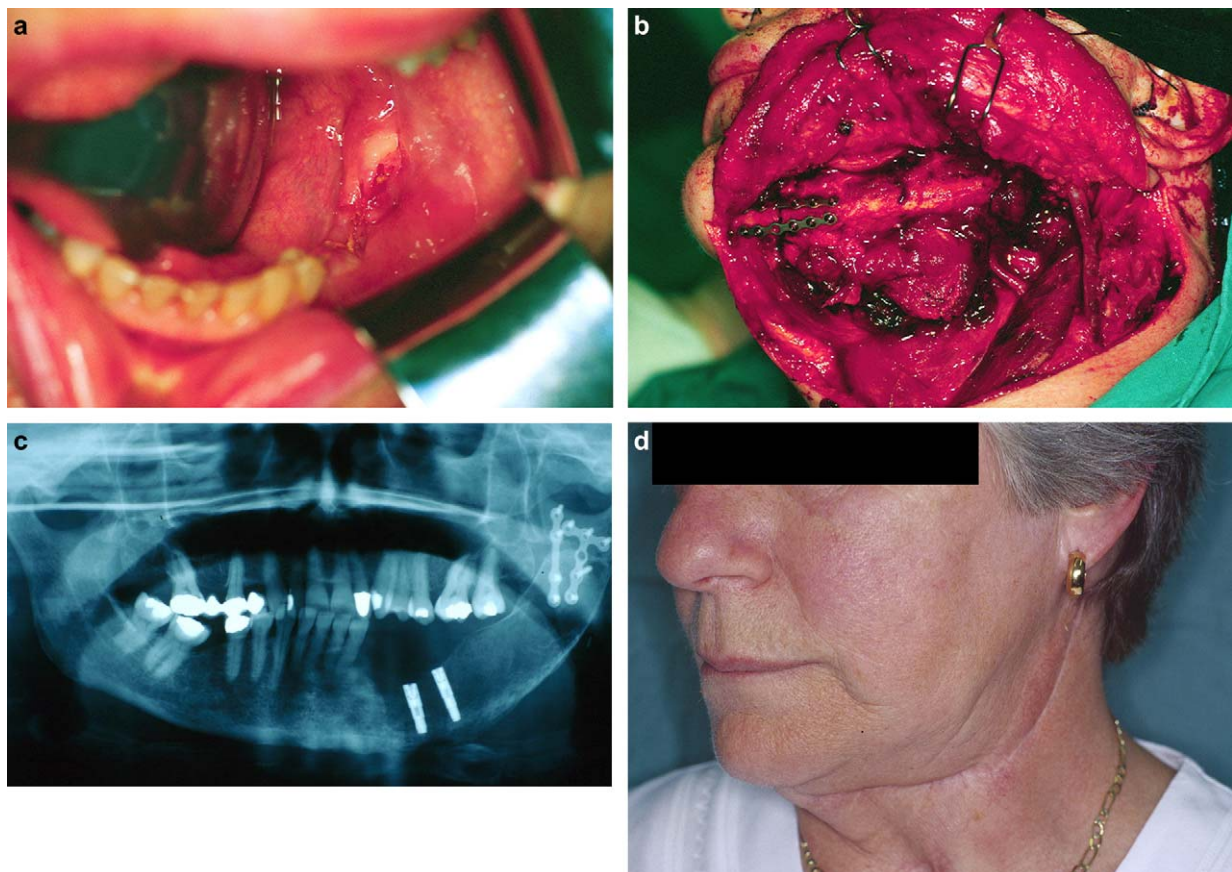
(a) Squamous cell carcinoma of the left posterior mandible. (b) Mandibular resection with reconstruction. (c) Postoperative panoramic radiograph showing placement of plants and implants. (d) Six months post surgery, showing good aesthetic results.
